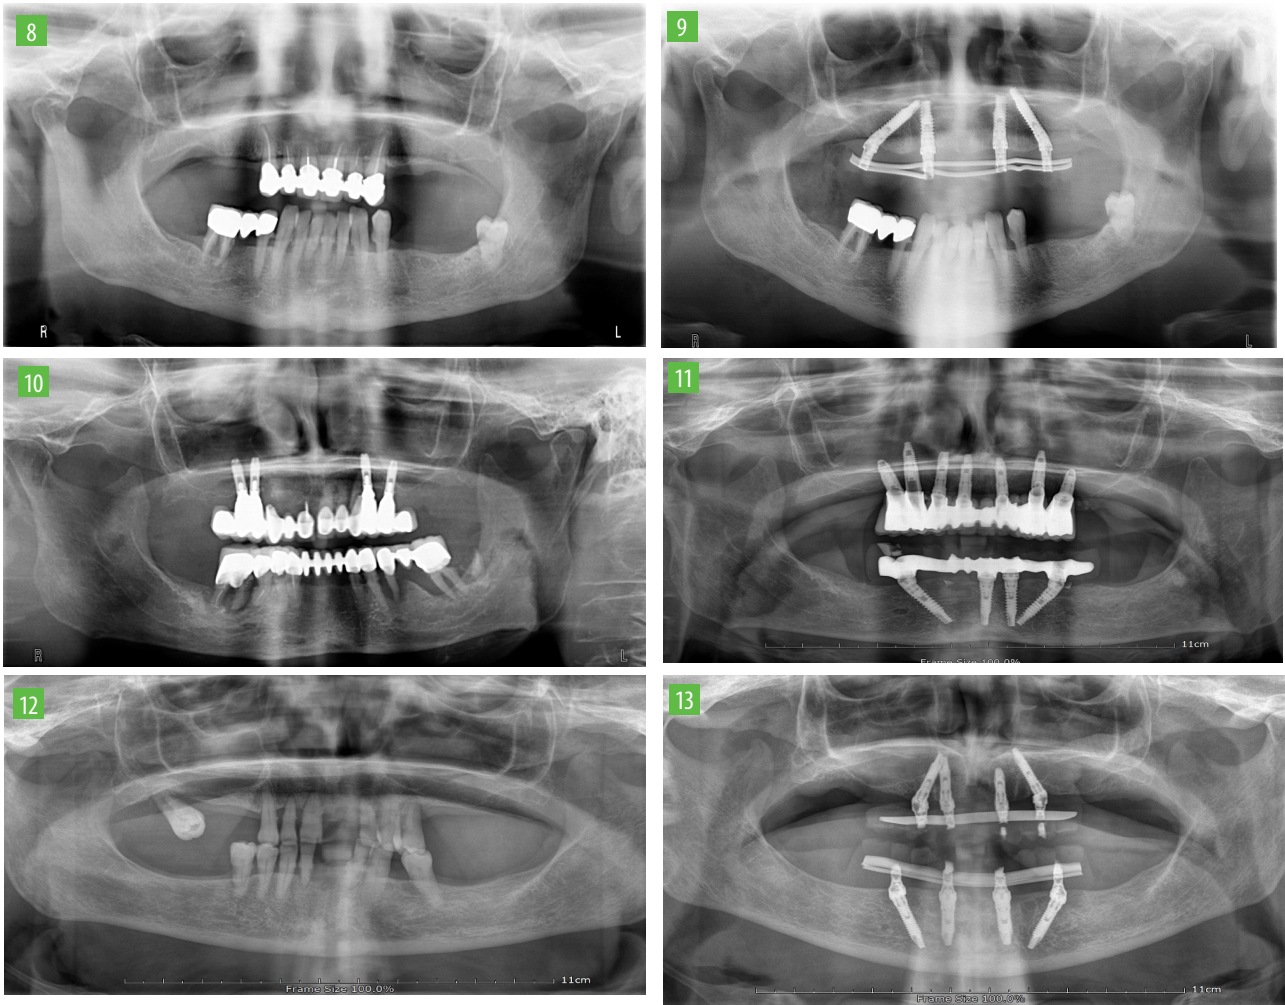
Post op x-ray. Multiple dental extractions
